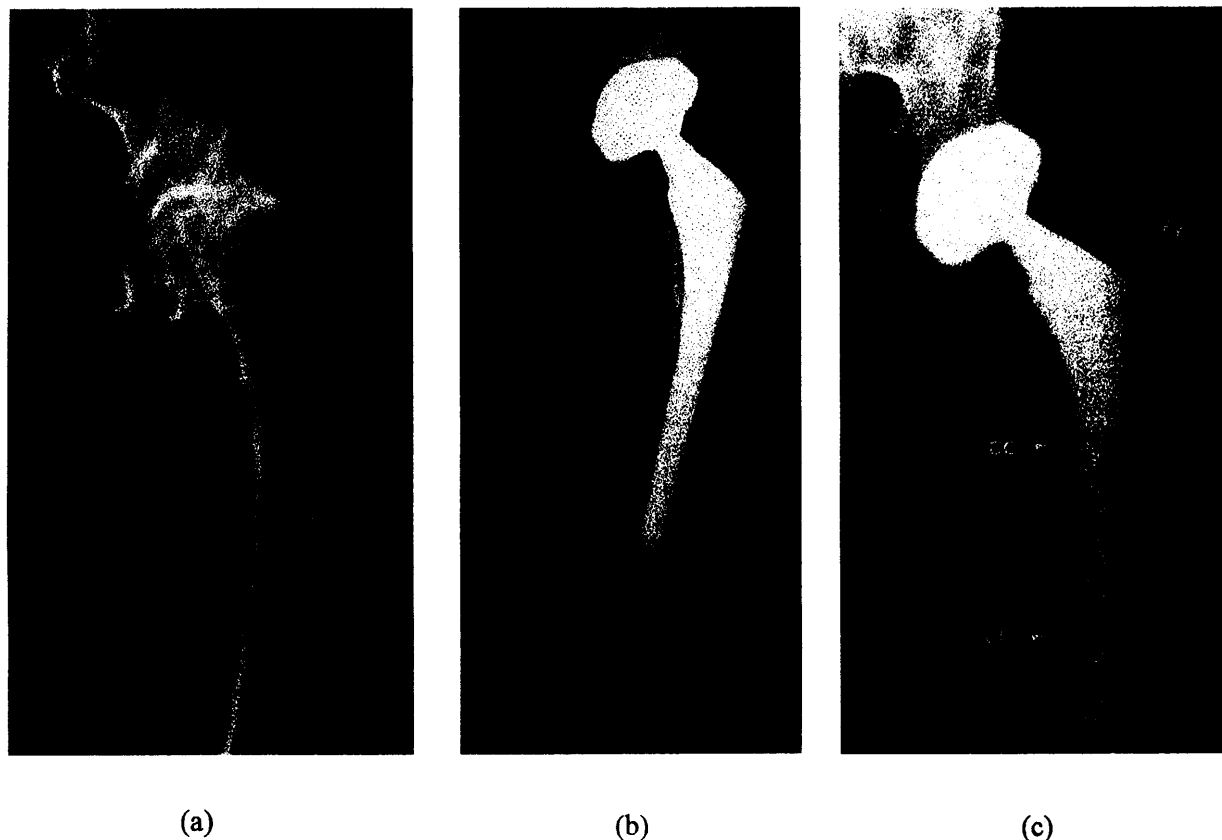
Radiographs of a 54-year-old woman who had osteoarthrosis and type-C bone. (Courtesy of D'Antonio et al.¹⁴⁵) (a) Preoperative radiograph. The joint space is obliterated, with partial collapse of the femoral head and periarticular osteophyte formation. (b) Anteroposterior radiograph made 6 weeks postoperatively. (c) Anteroposterior radiograph made 6 years postoperatively, showing the full extent of the cancellous condensation adjacent to the middle and distal portions, and cortical hypertrophy in Zones 2, 3, and 5.
